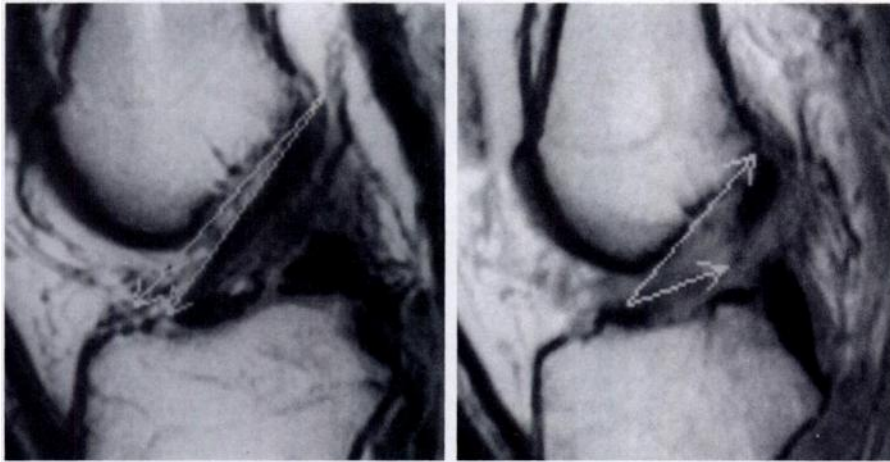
The ACL-Blumensaat line angle is measured between the posterior surface of the femur and the distal portion of the ACL. The angle has a negative value when the apex points superiorly and a positive value when the apex points inferiorly. (a) Sagittal (2,100/20) MR image shows ACL-Blumensaat line angle of -7° in a 55-year-old man with intact ACL at arthroscopy. (b) Sagittal (2,000/30) MR image shows ACL-Blumensaat line angle of $+32^\circ$ in a 35-year-old man with ACL tear at arthroscopy.
